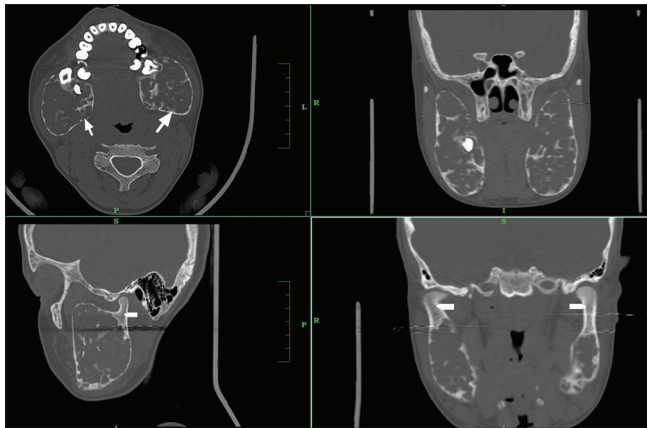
Axial, Coronal and Sagittal CT images showing bilateral symmetrical expansile predominantly lytic lesions involving the body, rami and coronoid processes of bilateral mandible (arrows). Typical sparing of condyloid process of mandible (arrow heads) seen
